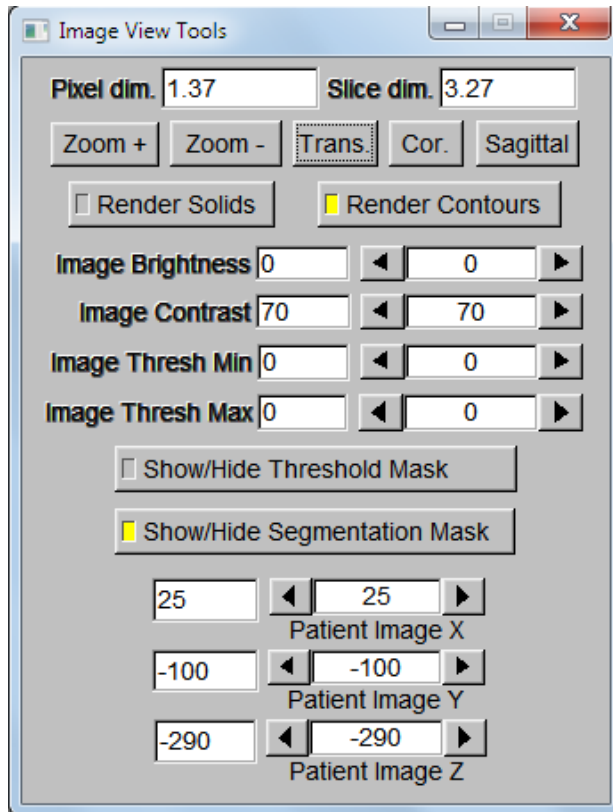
GUI of image view tools for CT image display.
